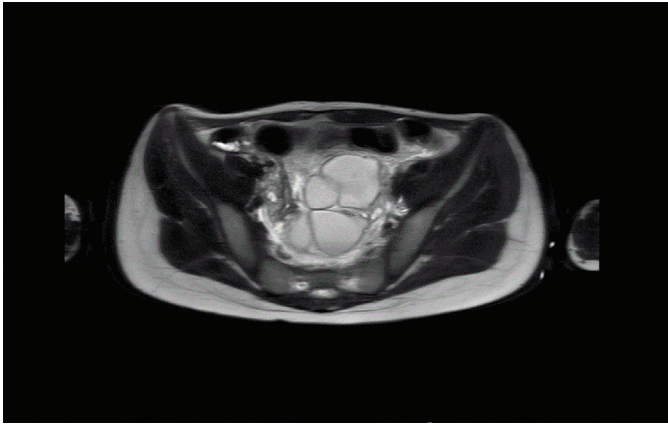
Axial pelvic magnetic resonance imaging (MRI) at the time of hospitalisation. The multiloculated mass demonstrates diffuse wall thickening and perilesional inflammatory changes consistent with Tubo-ovarian abscess formation. The multiple communicating cystic spaces of the lesion are clearly depicted.
